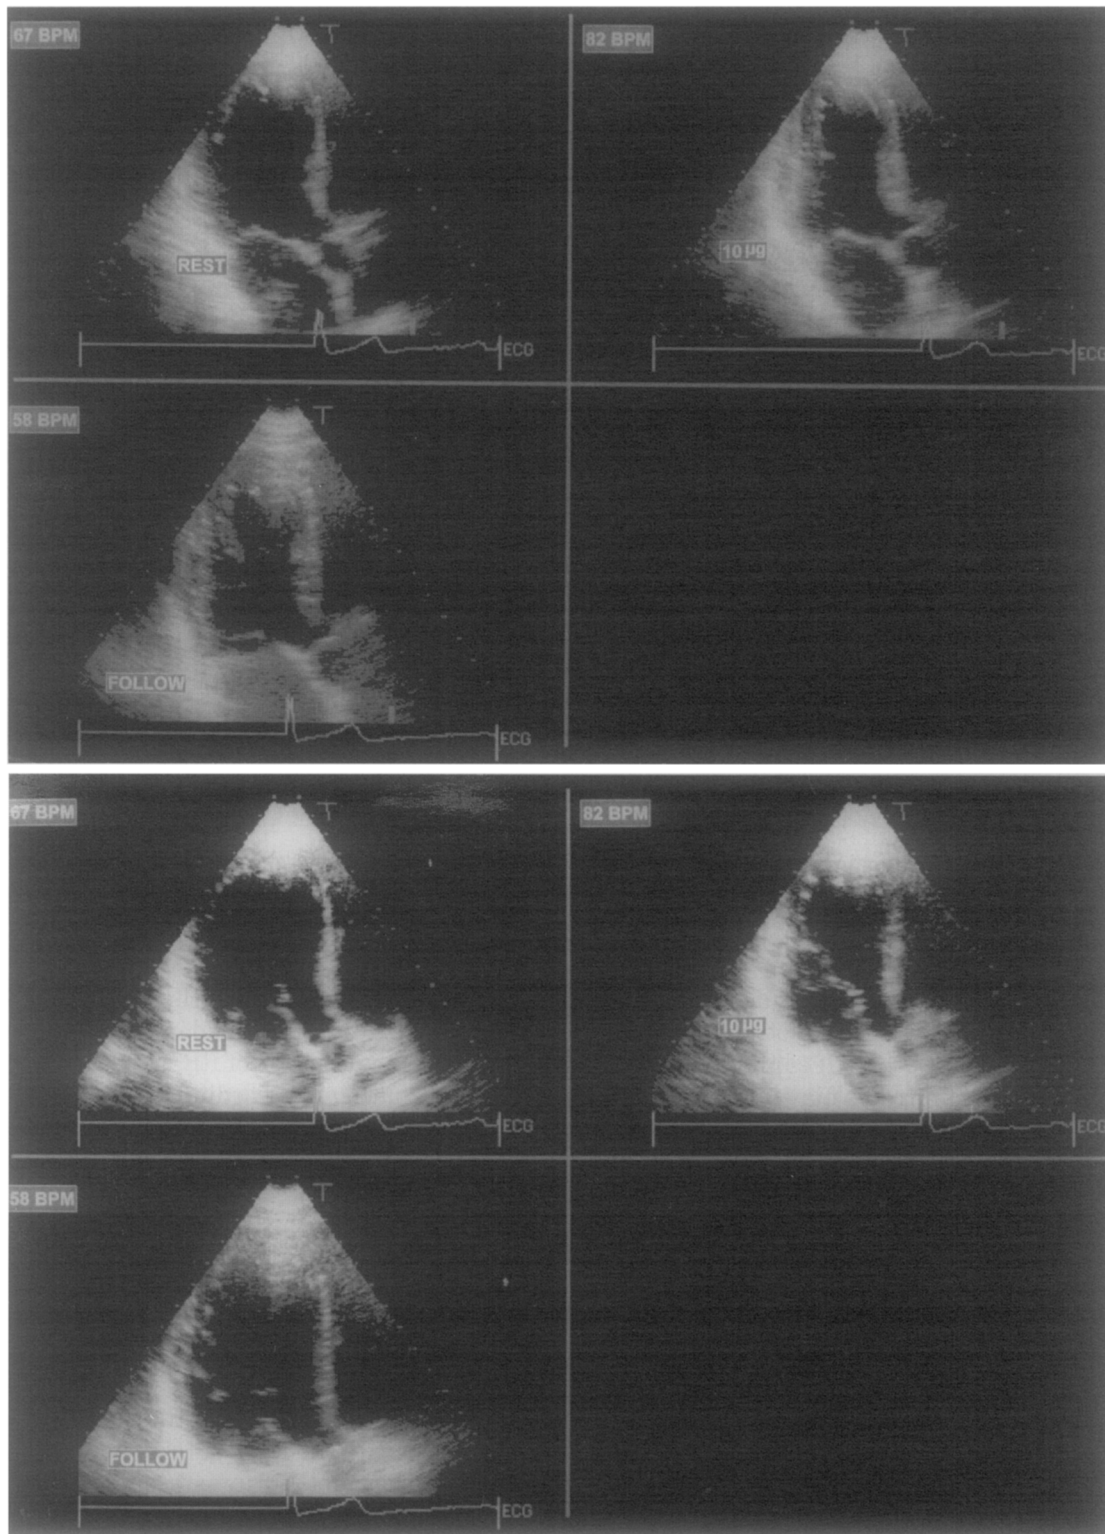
Same patient as in Fig. 5. Systolic (*top*) and diastolic (*bottom*) echocardiographic frames in apical long-axis view of same patient at rest, low-dose dobutamine (10 µg/kg/min), and at follow-up shows hypokinesis of anterior septum at rest, with improvement of thickening at low-dose dobutamine. Follow-up resting echocardiogram performed after 3 months shows improvement of thickening of anterior septum.
